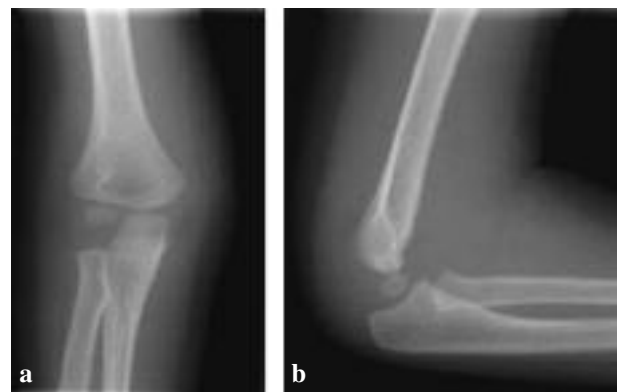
Anteroposterior (a) and lateral (b) radiographs of the elbow at time of trauma.
